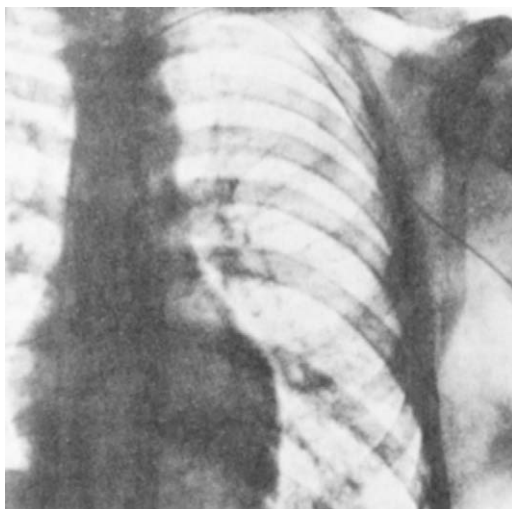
Original radiograph of Forssmann's placement of a catheter into his right atrium. (From Forssmann W. The catheterization of the right side of the heart. *Klin Wochenschr* 1929;8[2085]:2087. With kind permission from Springer Science+Business Media.)
